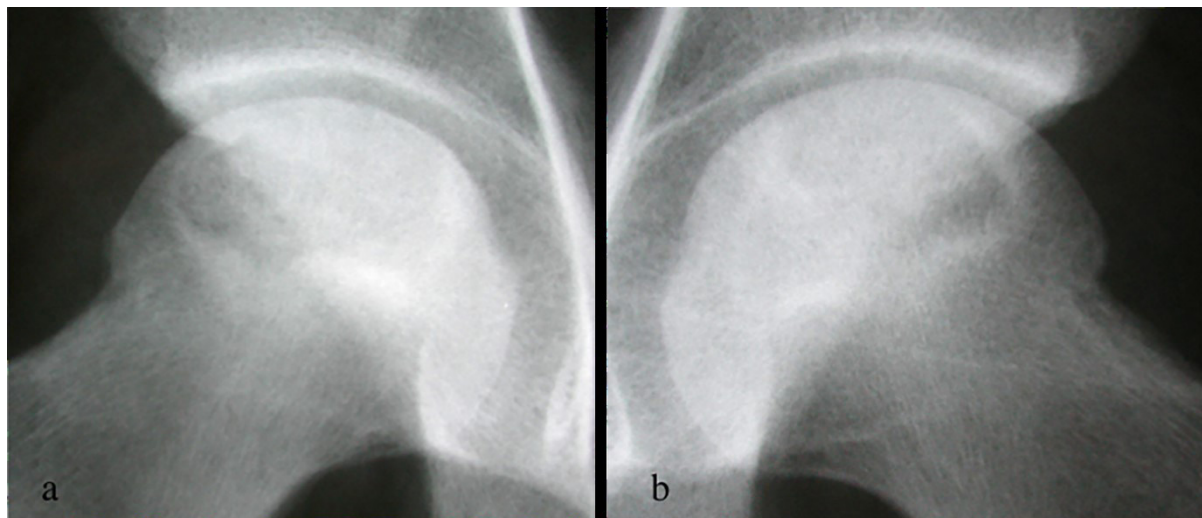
a & b: Bilateral FHON: Patient claimed for a vague groin pain on his right hip (a), reflecting to the medial aspect of the thigh and buttock. Careful clinical evaluation revealed restricted motion of the right hip joint and pain mainly elicited in flexion and internal rotation of both hips. Radiographic evaluation revealed bilateral FHON.
